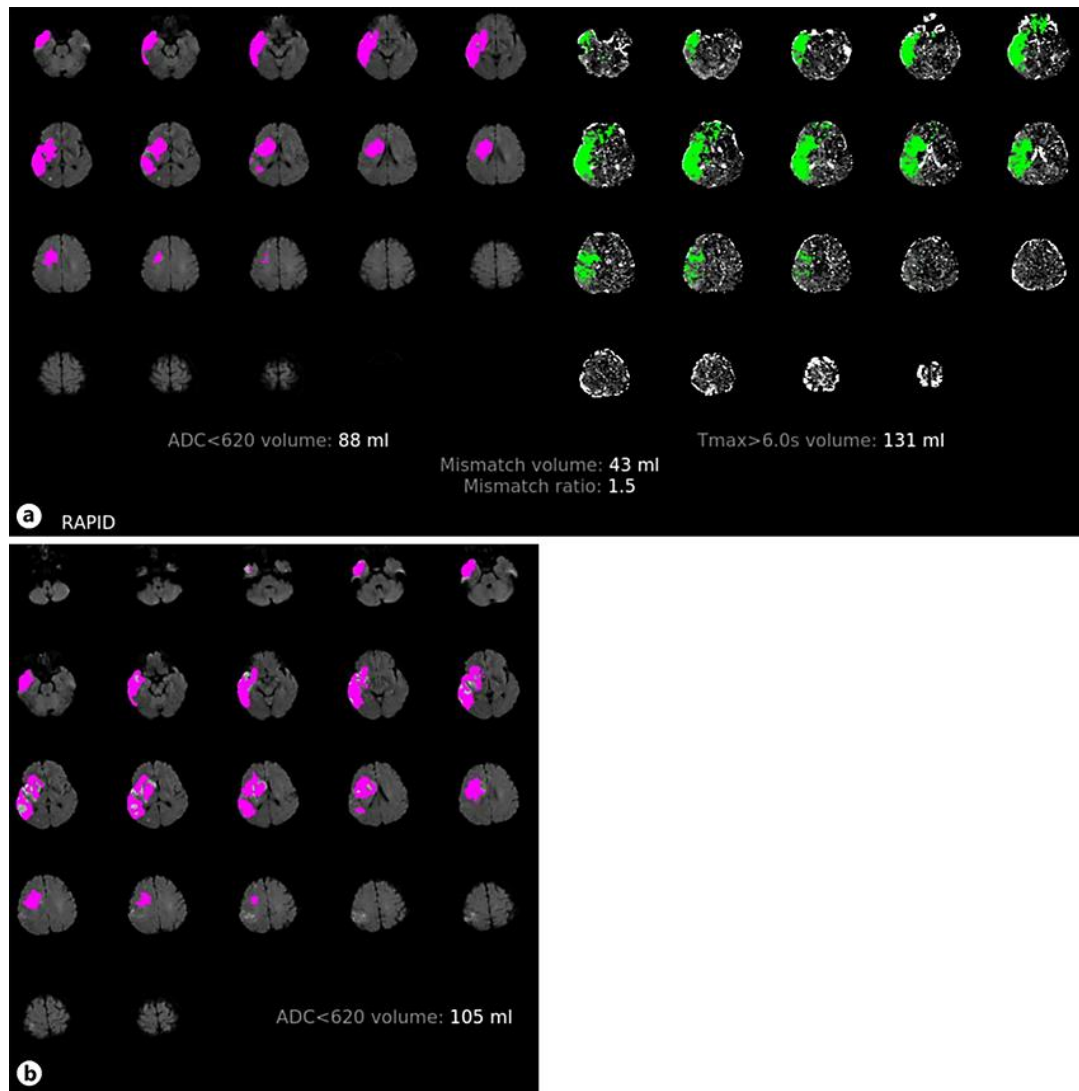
Perfusion magnetic resonance imaging with RAPID software showed a large mismatch volume (a). Perfusion imaging was repeated to estimate the final infarct core volume (b), demonstrating that 26 mL of the penumbra was saved.
